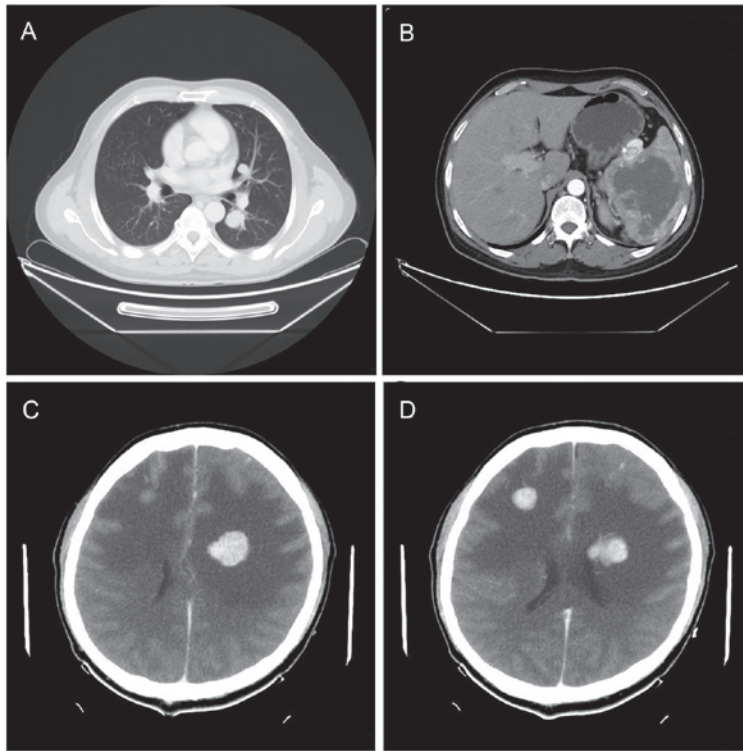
Computed tomograph images revealing the multiple metastases of (A) the lung, (B) the spleen and (C and D) the brain.
